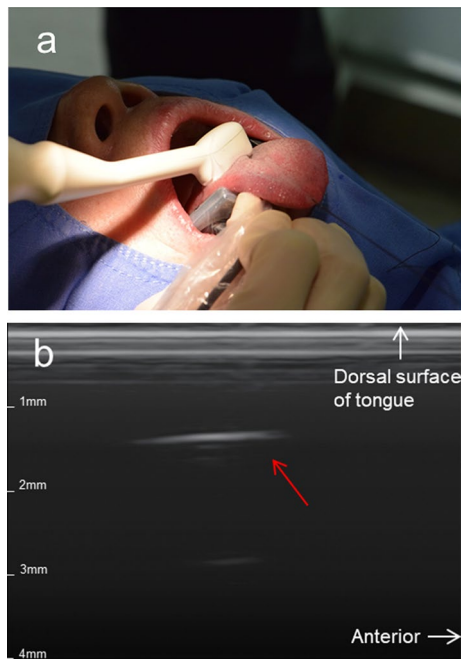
a The intraoral transducer and X-ray film were applied below and above the tongue, respectively. The intraoral transducer was placed transversely on the tongue. b Ultrasound image of the foreign body (red arrow) when the intraoral transducer was applied longitudinally on the tongue
